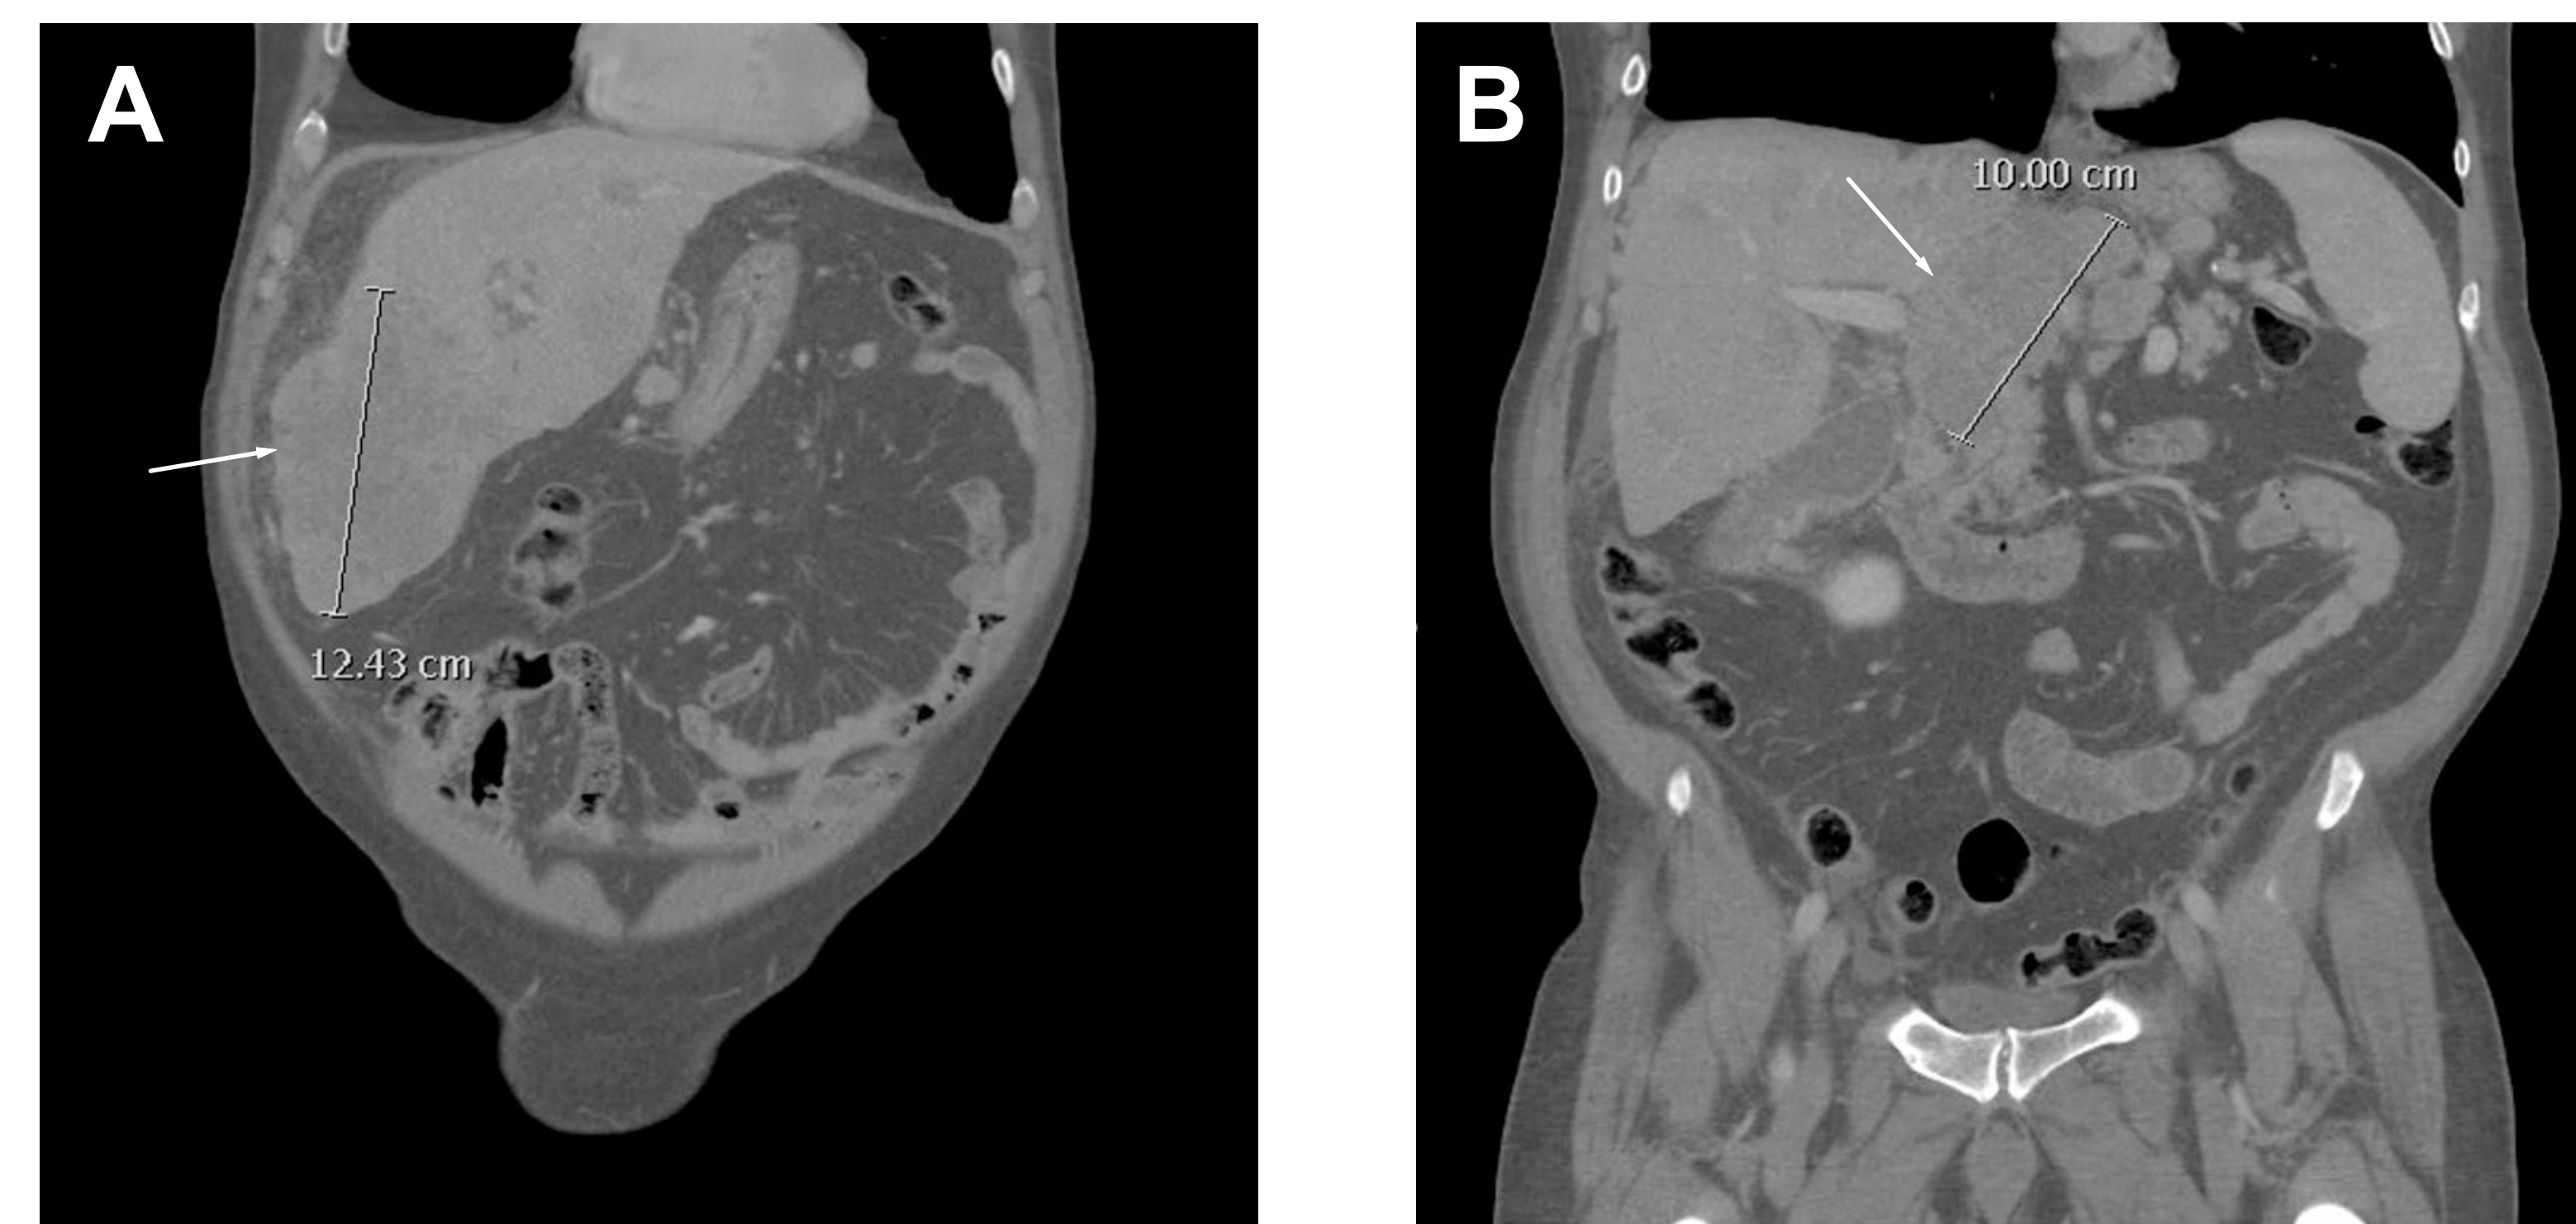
CT Scan of the Abdomen and Pelvis
